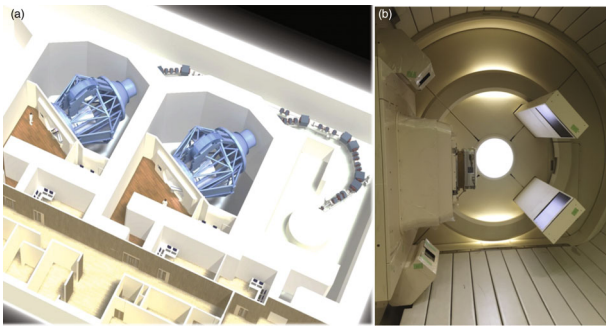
(Color online) (a) Layout of the proton therapy center that has two conventional gantries with a cyclotron at Samsung Medical Center. (b) X-ray imaging system for the proton therapy machine, which has an option for real-time imaging during treatment.
